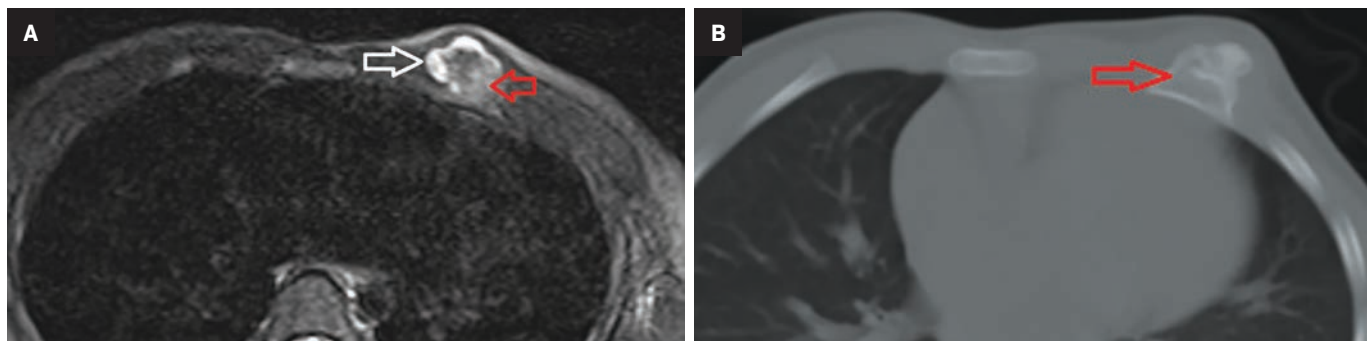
(A) Axial T2 fat-suppressed MR image showing a mass projecting anteriorly from the left third rib (red arrow). Note the T2 hyperintense cartilaginous cap of the lesion (white arrow). (B) Chest CT demonstrates corticomedullary continuity with the adjacent rib. Findings are consistent with an osteochondroma.
